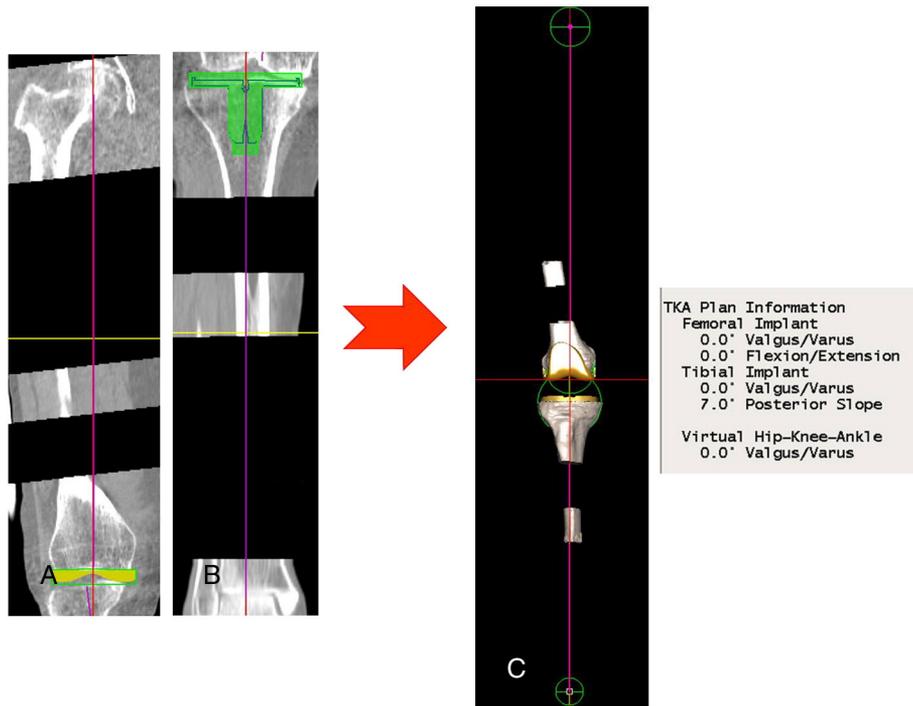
Preoperative planning classical method. (A) Femoral component alignment and resection planned on CT scan data. Femoral mechanical axis (magenta line) and implant axis (red line) are parallel to each other and femoral bone cut is perpendicular to mechanical axis. (B) Tibial component alignment. Proximal tibial cut is planned at 90° to mechanical axis and implant axis is parallel to mechanical axis. (C) Virtual implant placement in knee and the final plan information.
